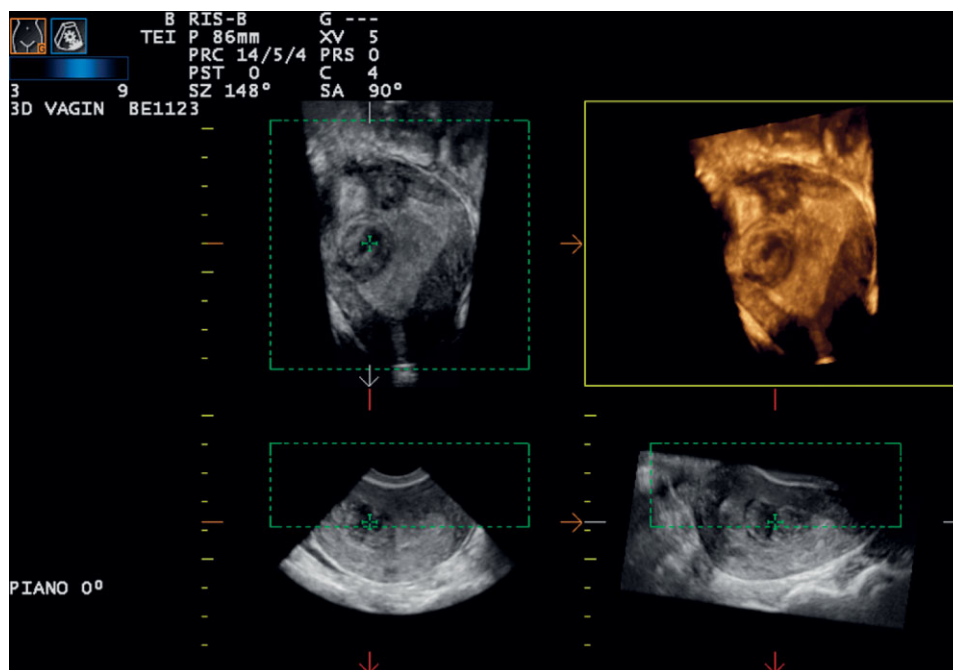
Manipulation of three-dimensional ultrasound volume with multiplanar technique in order to examine the uterine cavity and protrusion of fibroids.
